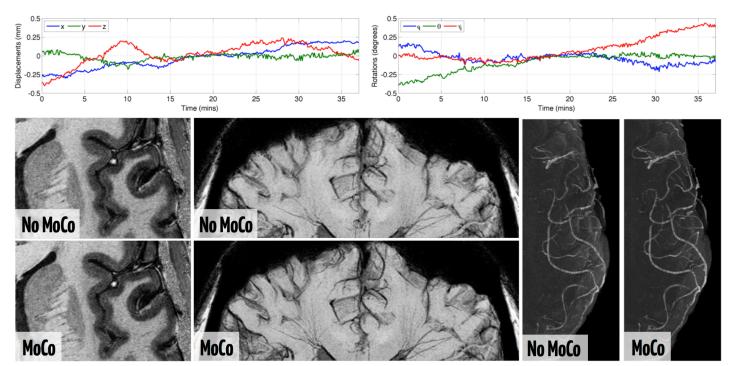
Top – estimated motion parameters from FatNavs. Bottom – (left) zoom of low-bias T1-weighted contrast; (middle) zoom of minimum intensity projection of INV<sub>2</sub> over 15 mm thickness to visualize veins; (right) maximum intensity projection of INV<sub>2</sub> over whole 80 mm slab to visualize arteries.
